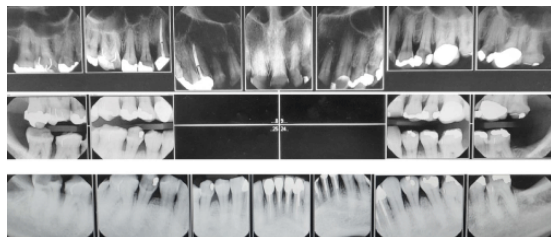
Preoperative full-mouth radiographs.
